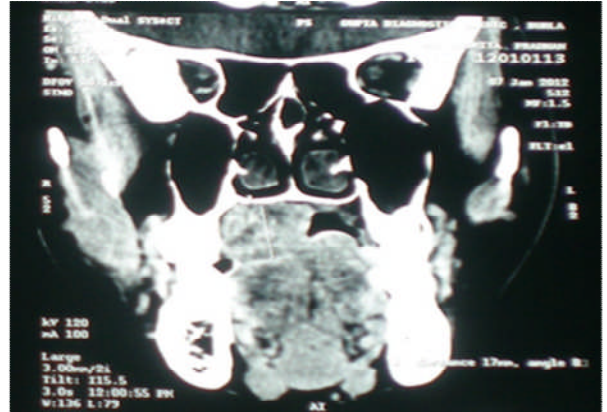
CT Scan showing the lesion without any underlying bone destruction but compressing the tongue
